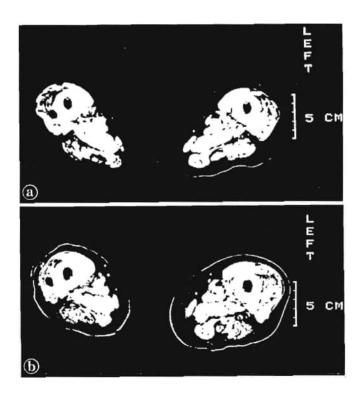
CT image before and after 3 months of TES therapy Cross section of the bilateral thighs before (a) and after (b) TES therapy
